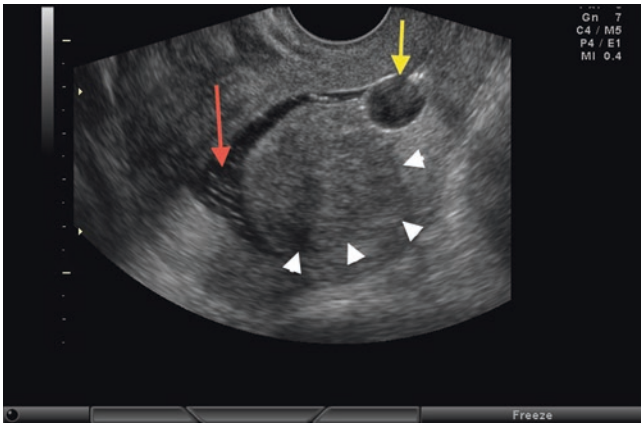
Hysterosonography, showing longitudinal section of the uterus. The *yellow arrow* indicates the catheter balloon used. The *red arrow* shows liquid infused into the endometrial cavity. The *heads of white arrows* show a large submucosal nodule (myoma). Note that — unlike the polyps — the endometrial interface with the myometrium is poorly defined due to the presence of the nodule
